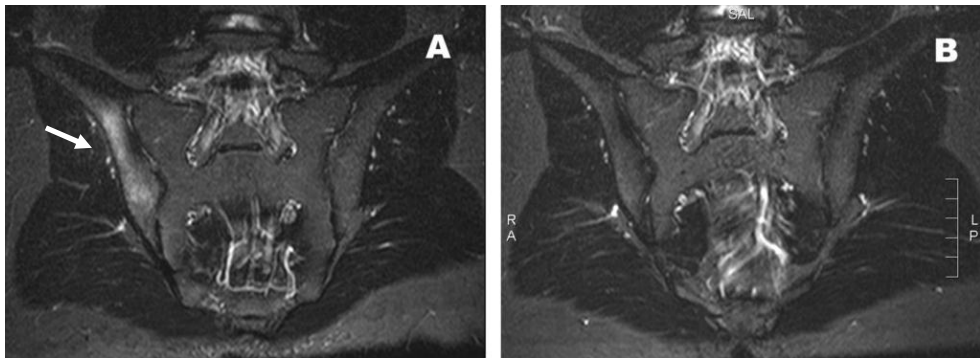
(A). Pre-pamidronate treatment (MRI) with gadolinium demonstrates enhancement consistent with inflammation in the right sacroiliac area. (B). Post treatment MRI with Gadolinium 6 weeks after first treatment with pamidronate: No enhancement (Miettunen, Wei et al. 2009).
